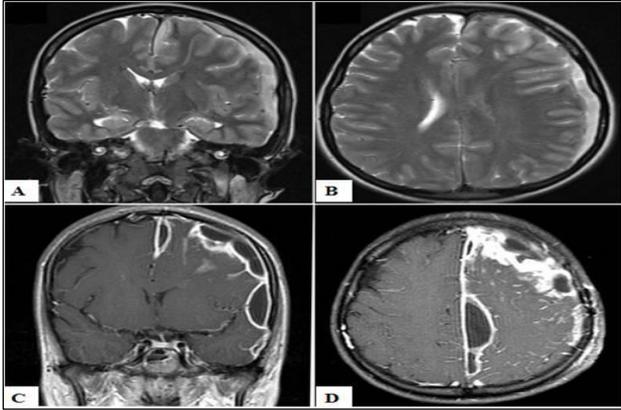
Coronal section (a) and axial MRI sections (b) of frontotemporoparietal subdural empyema before the first surgery. Coronal section (c) and axial MRI sections (d) of frontotemporoparietal subdural empyema revealing cystic enlargement, abscess' wall thickening and contrast enhancement of previous lesions 2 months after the first surgery.
